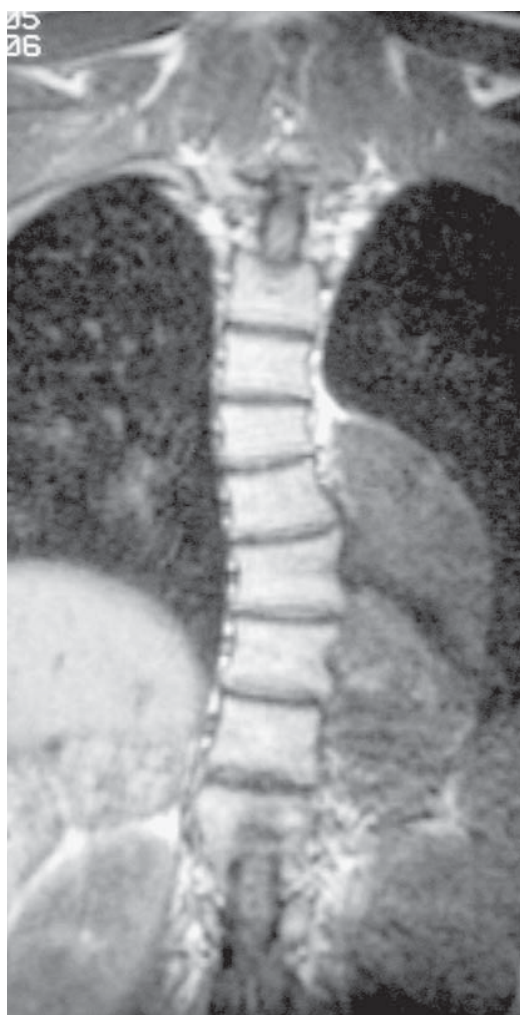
Coronal T1W MRI in the mid-thoracic region showing a neurofibroma adjacent to the convexity of the curve and associated with minor lateral vertebral scalloping
